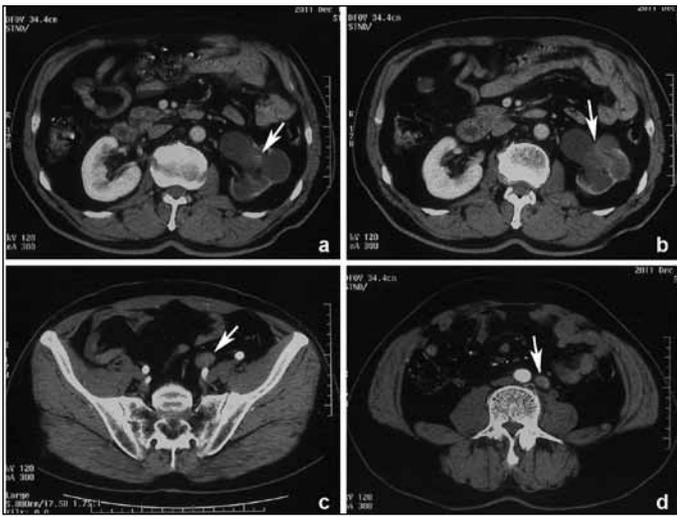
Contrast-enhanced computed tomography demonstrates (a, b) left pelvic tumour; (c) ureteral tumour; and (d) a swelling para-aortic lymph node (arrow).
